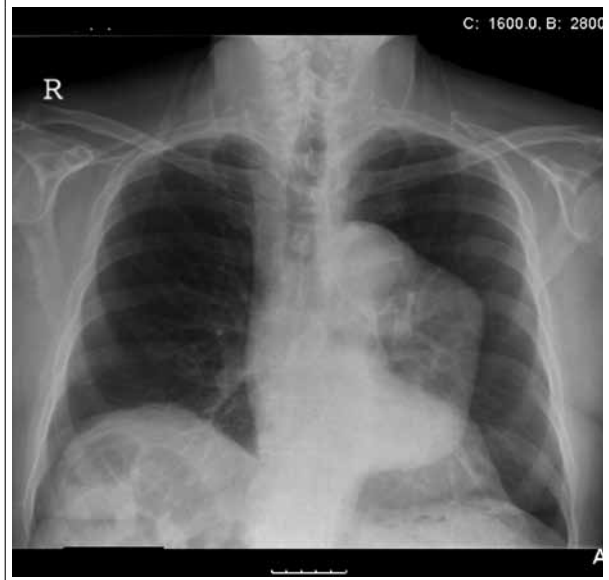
Chest X-ray in 2008
